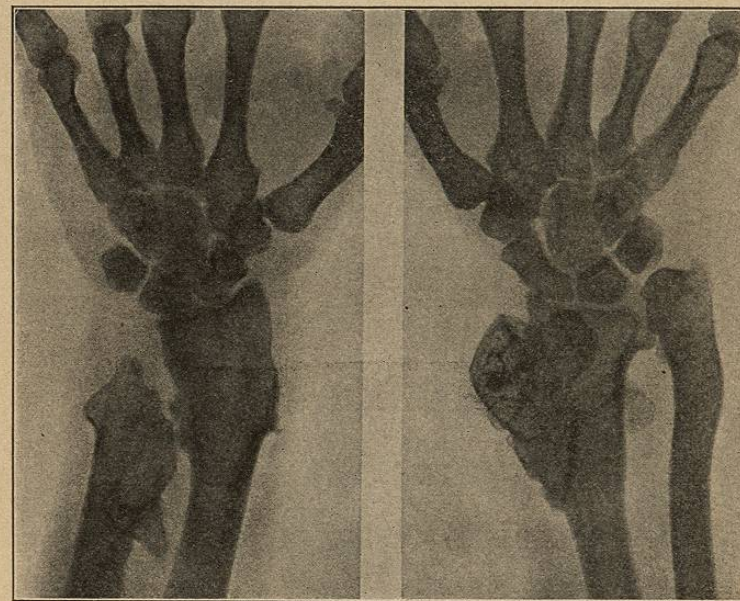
Radiograph of the Wrists in Hypertrophic Pulmonary Osteoarthropathy. (v. Ziemsen's Atlas.)
